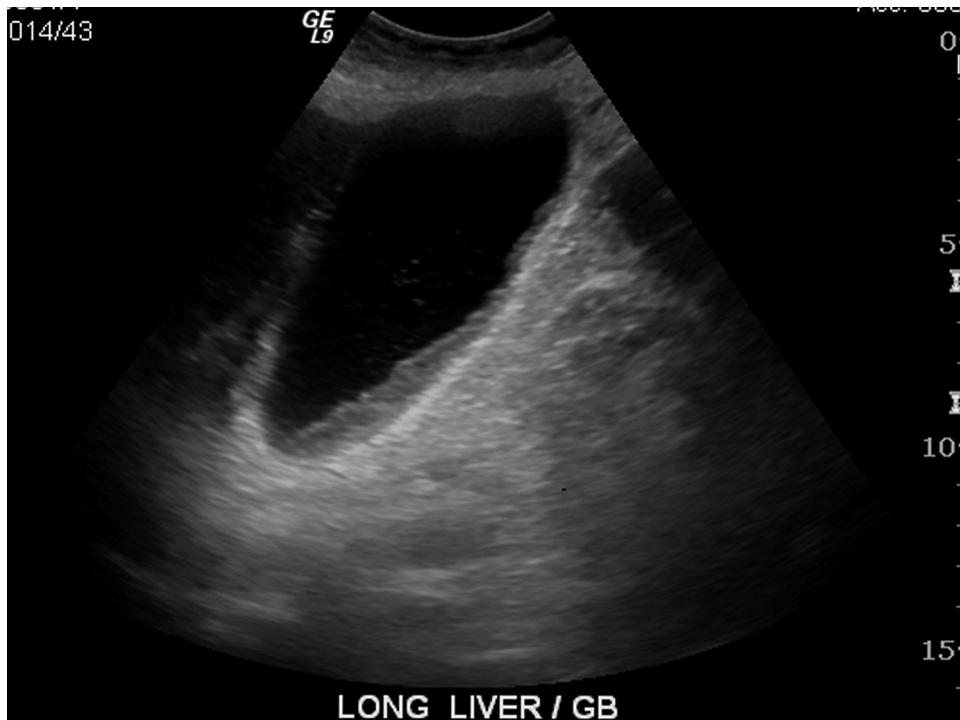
Abdominal ultrasonogram showing the presence of pericholecystic fluid and absence of calculi, consistent with acalculous cholecystitis.
